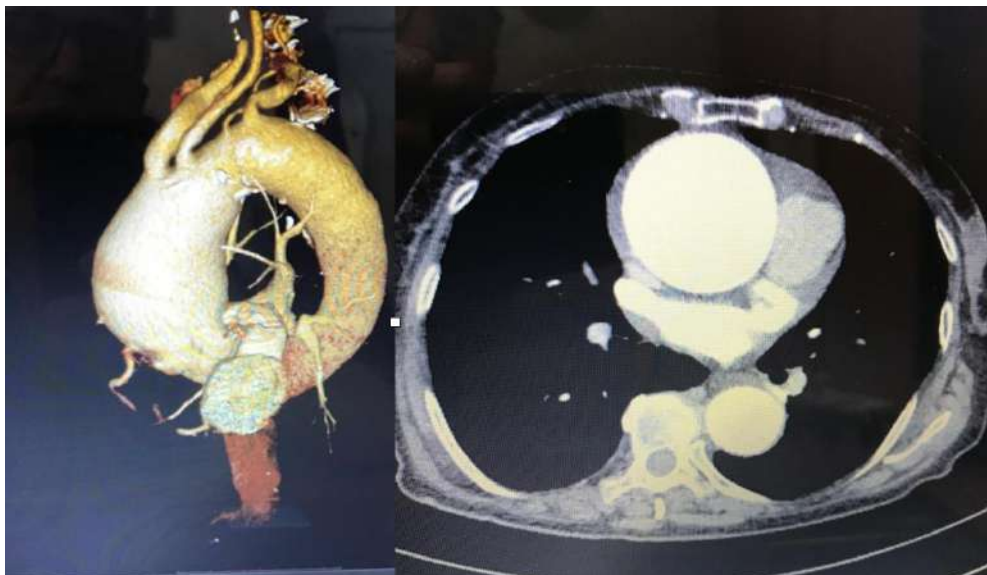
CT-scan revealed the presence of an aortic root aneurysm without signs of rupture or active bleeding.
